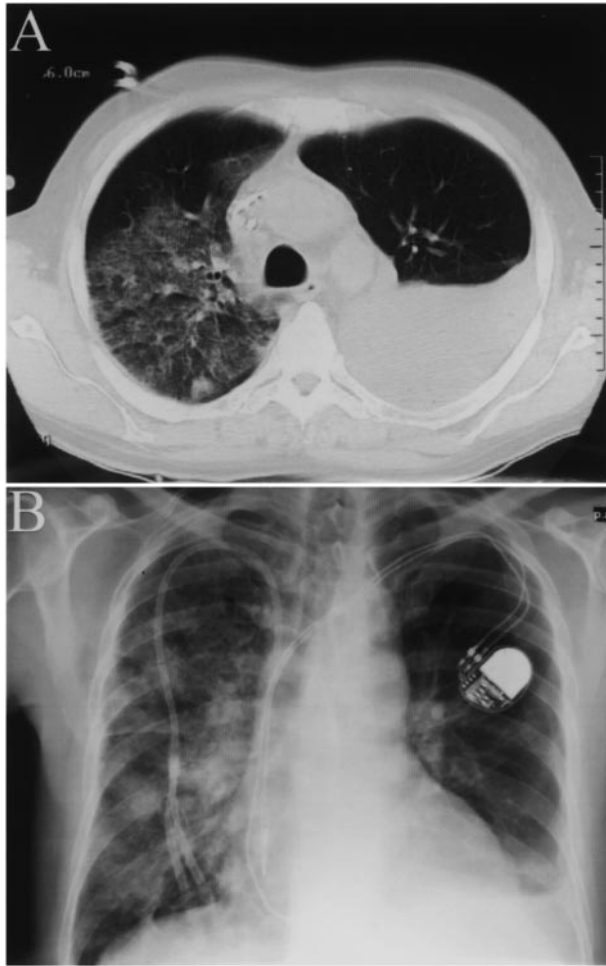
(A) CT scan of the chest showing a large left pleural effusion and ground glass opacities in the right lung indicative of drug-induced lung toxicity. (B) Chest radiograph post thoracentesis revealing normal left lung parenchyma with a minimal left pleural effusion and unchanged right lung parenchymal opacities.
